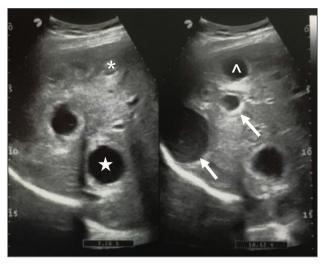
Liver ultrasound. Liver ultrasound performed by an expert hepatologist showed multiple spheric lesions between 1 and 6 cm, some appearing as unilocular anechoic spaces with thin walls (star); others appearing as relatively hypoechoic lesions with mural thickening, hyperechoic walls, and debris-containing fluid (arrow). Cist aspiration (-) and targeted liver biopsy were performed (*).
